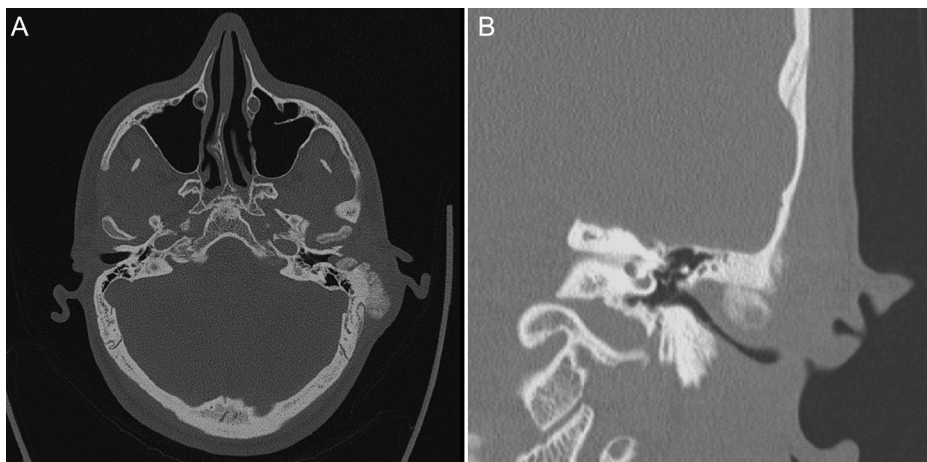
Preoperative computed tomography scan of the left temporal bone. (A) Axial view showing a hyperostotic exophytic lesion, measuring up to 3 cm in diameter. (B) Coronal view showing posterior external auditory meatus infiltration and no tumor in the tympanic cavity.
